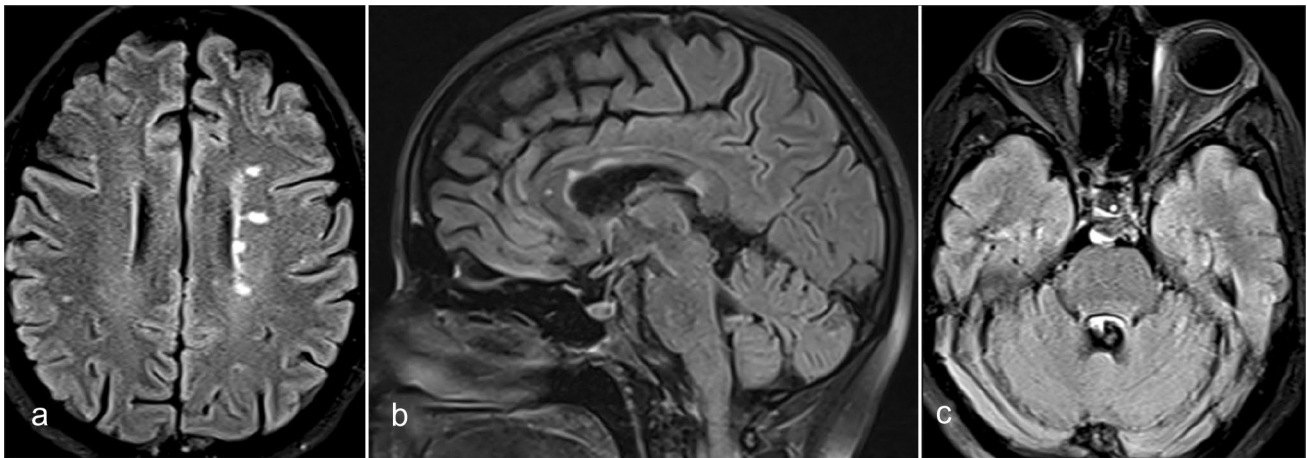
MRI images (a–c) shows multiple FLAIR hyperintense lesions oriented perpendicular to the periventricular origin (a) and involving callosal-septal interface (b). FLAIR hyperintensity is also seen along left optic nerve (c). These imaging features are in favour of demyelination disease (multiple sclerosis)
